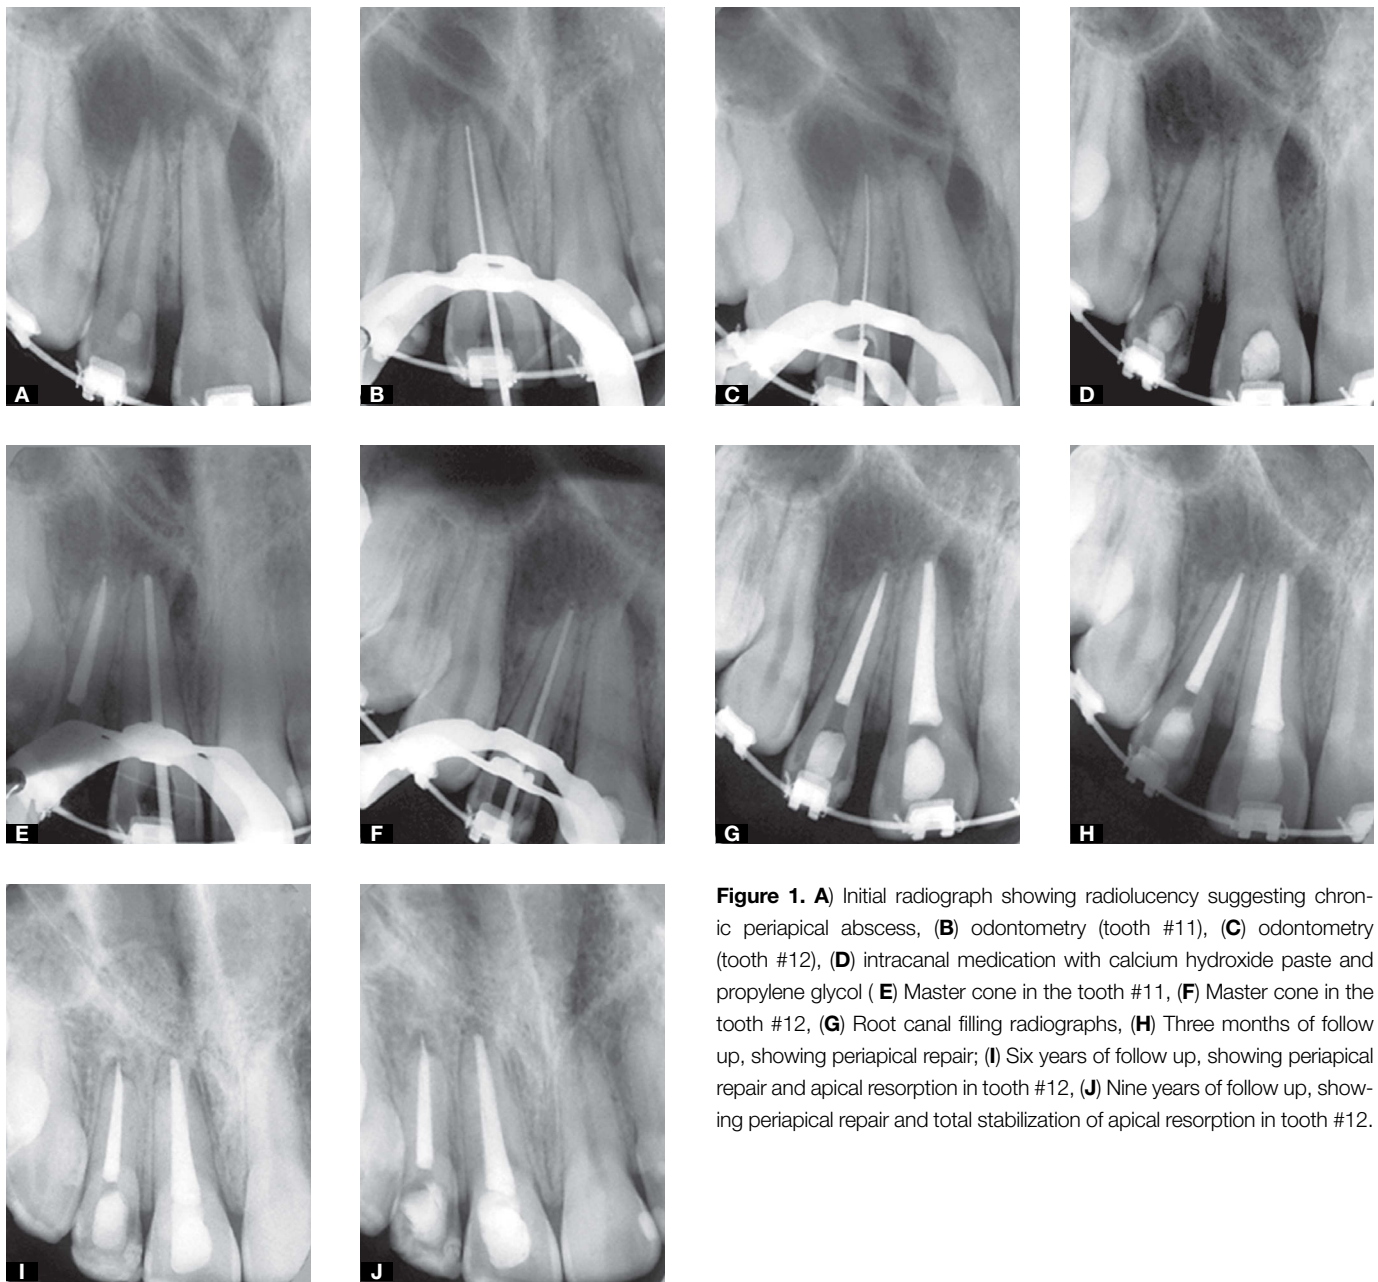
A) Initial radiograph showing radiolucency suggesting chronic periapical abscess, (B) odontometry (tooth #11), (C) odontometry (tooth #12), (D) intracanal medication with calcium hydroxide paste and propylene glycol (E) Master cone in the tooth #11, (F) Master cone in the tooth #12, (G) Root canal filling radiographs, (H) Three months of follow up, showing periapical repair; (I) Six years of follow up, showing periapical repair and apical resorption in tooth #12, (J) Nine years of follow up, showing periapical repair and total stabilization of apical resorption in tooth #12.
